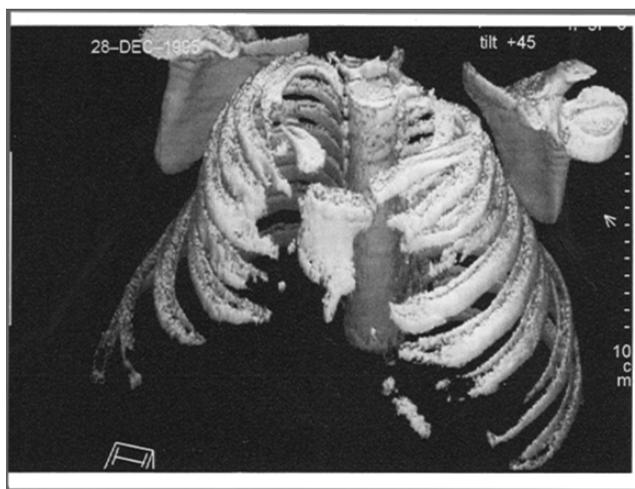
Reconstruction of a preoperative CT scan in a child with ATD 10 years after pectus repair showing a narrow upper chest cavity secondary to lack of rib growth (36).
